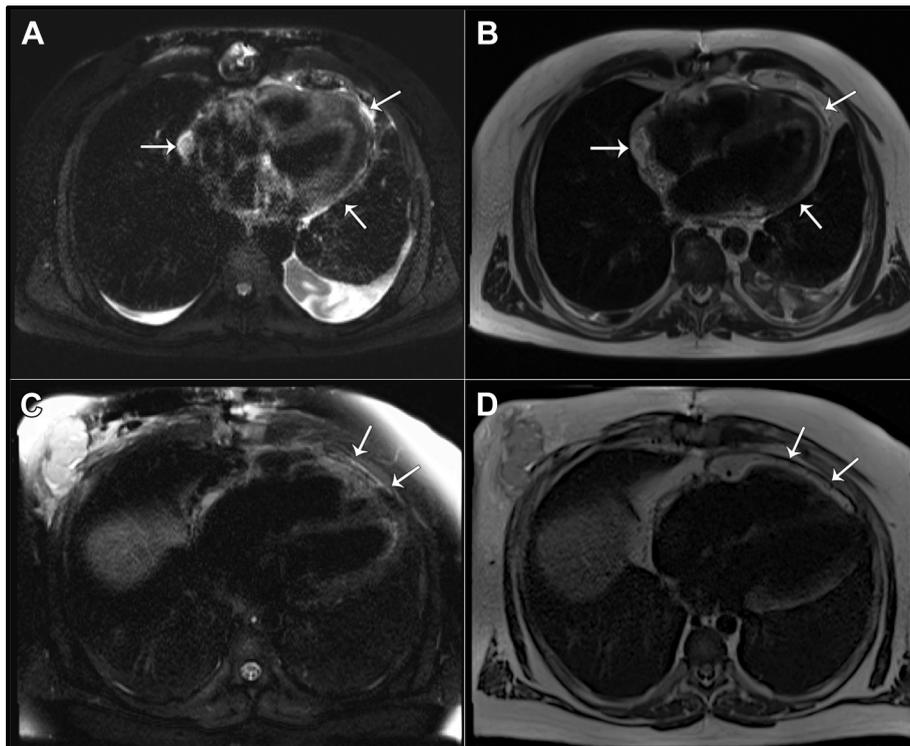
T2-weighted magnetic resonance images obtained on postoperative day 6 of the 56-year-old patient who did not receive an amniotic membrane patch (A, B) and the 24-year-old patient who did receive an amniotic membrane patch perioperatively (C, D). A, C, with fat suppression. B, D, without fat suppression to localize edema. *Arrows* indicate areas of extensive (A, B) or minimal (C, D) postsurgical inflammatory pericardial edema.
